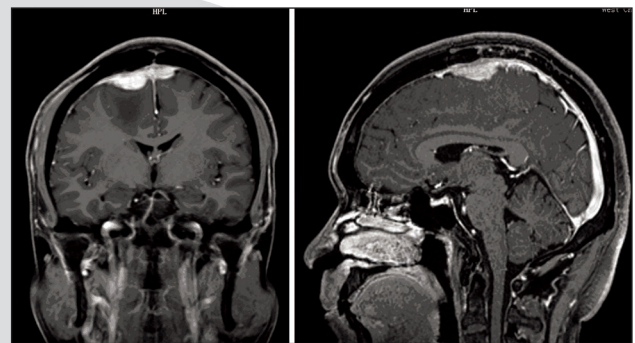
A MRI revealed an enhanced mass in pre-central gyri area with obvious edema and "dural tail" sign.
